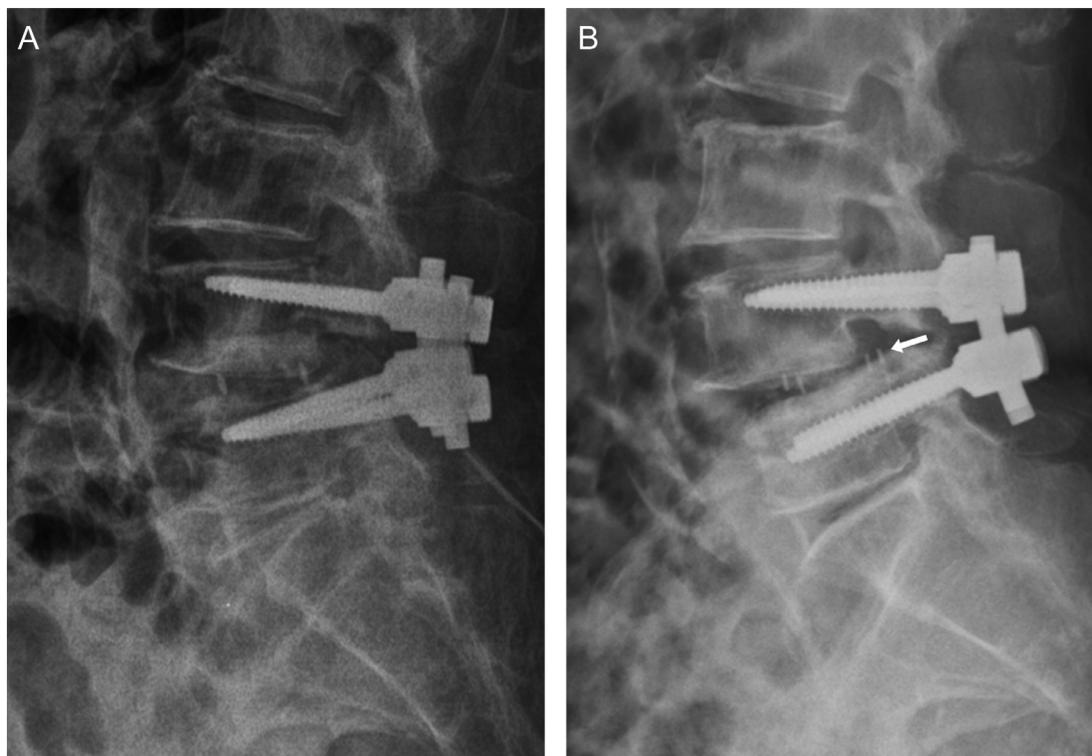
A case showing cage retro-pulsion following TLIF. (A) Immediate postoperative radiograph showing the size and location of both cages is appropriate. (B) Six months after surgery, the cage migrated into the spinal canal.
